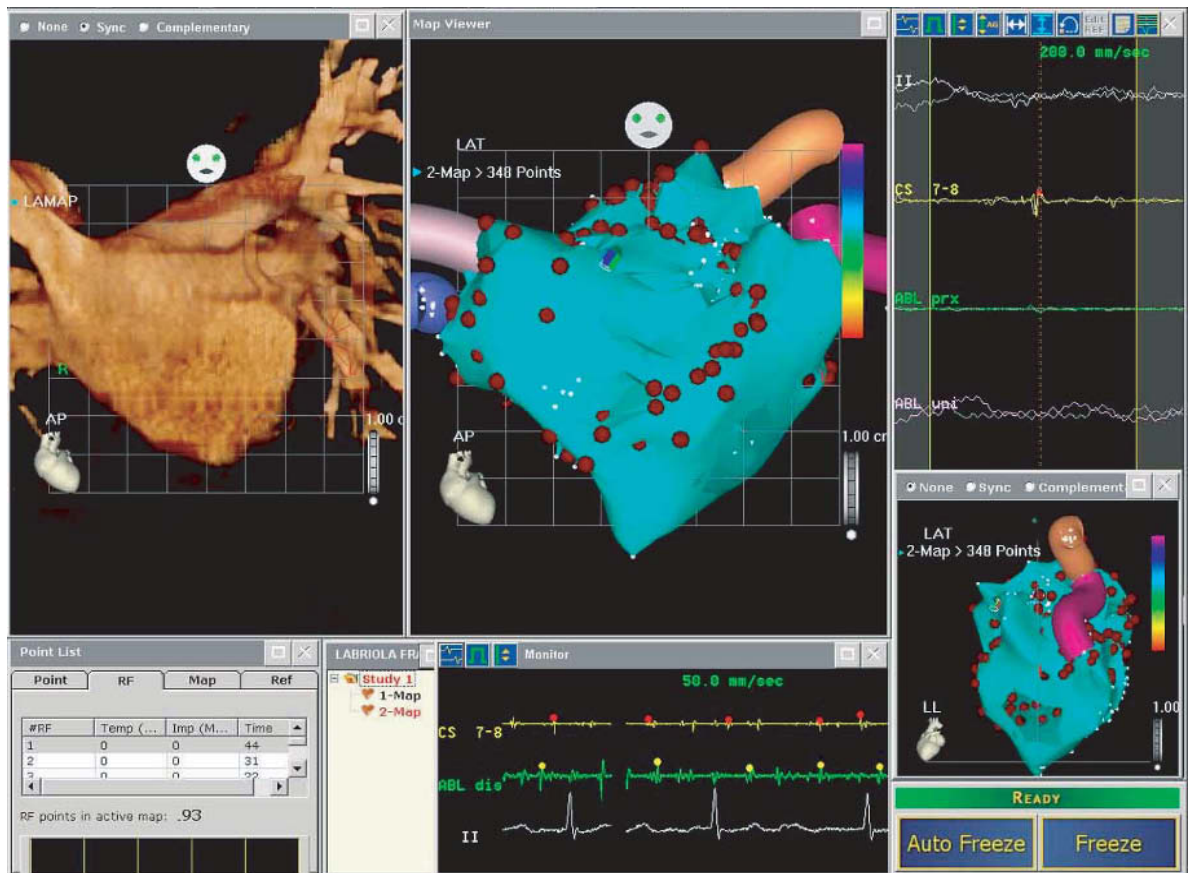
Screen shot of a planning workstation for performing RF ablation of the pulmonary veins. An AP view of the volume-rendered image (upper left) of the pulmonary veins and the left atrium generated from a 16-slice CT examination with 16×0.75 -mm collimation and 0.37-s rotation time. The same view can be generated on the mapping system, with red circles showing the ablation sites, as a basis for electrophysiological mapping of the ablation procedure
